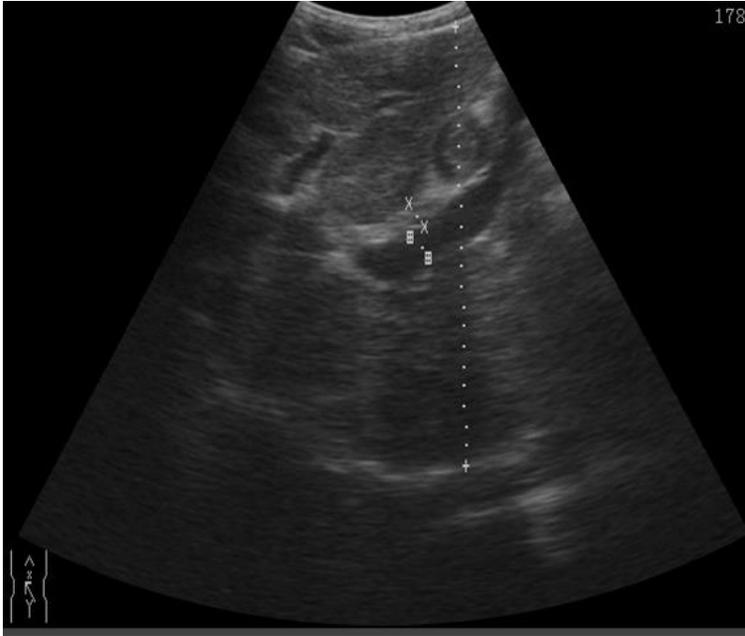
Ultrasound examination of patient 31 showing thickened periportal fibrosis and extended portal vein (portal hypertension) and granulomatous liver parenchyma.
